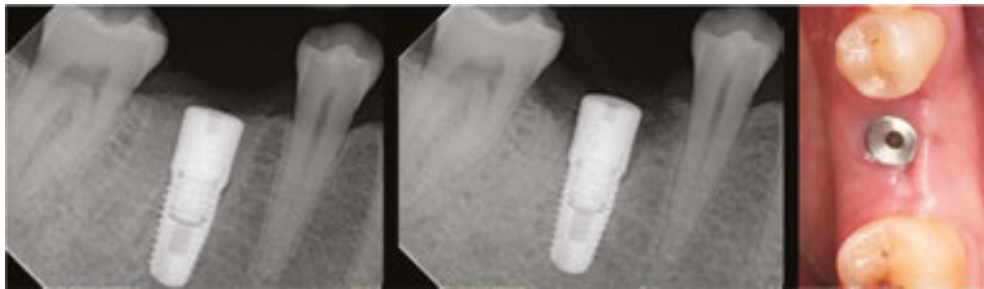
The radiograph on the left was taken immediately following the procedure. The one alongside was taken 3 months later as was the photograph. The case is now ready for a final restoration.
